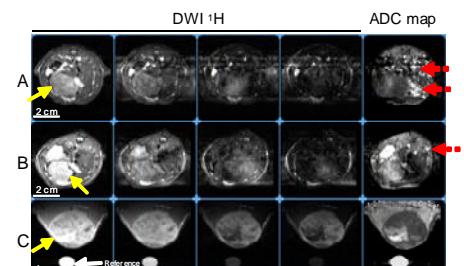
DWI and ADC maps of IH (A, B) and SC (C) HCCs at different  $b$ -factors (in  $\text{s/mm}^2$ ): a - 0, b - 256, c - 945, d - 1679. HCC is marked by yellow arrows and the motion artifact is marked by the dotted red arrows on the ADC maps.
